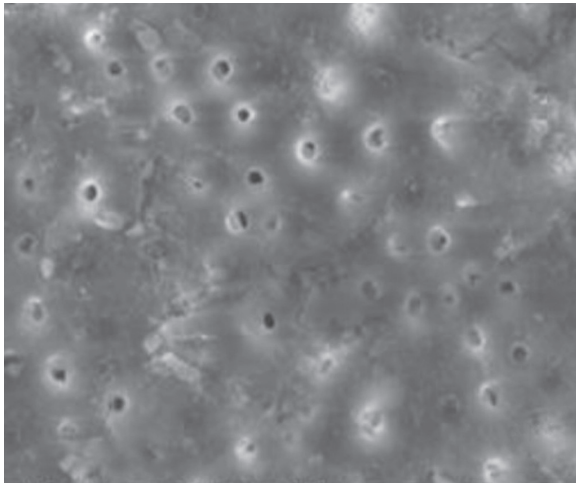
Ultrasonic group middle level (score 2)
